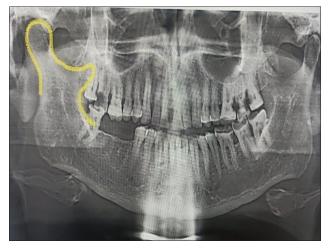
Orthopantomogram showing round condylar process with wide sigmoid notch
